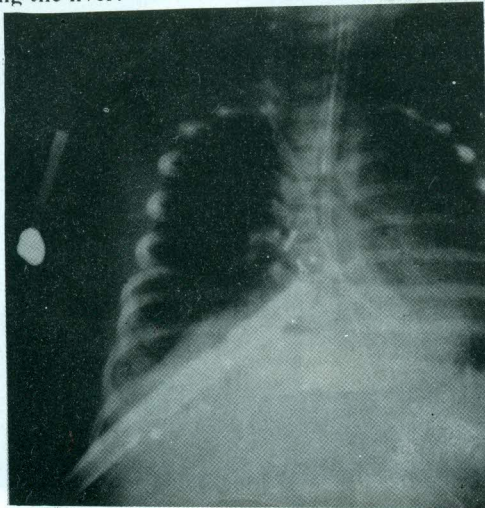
Postoperative chest x-ray shows clearance of the right hemithorax from the tumor. Intercostal chest tube is there. Patient is extubated.
